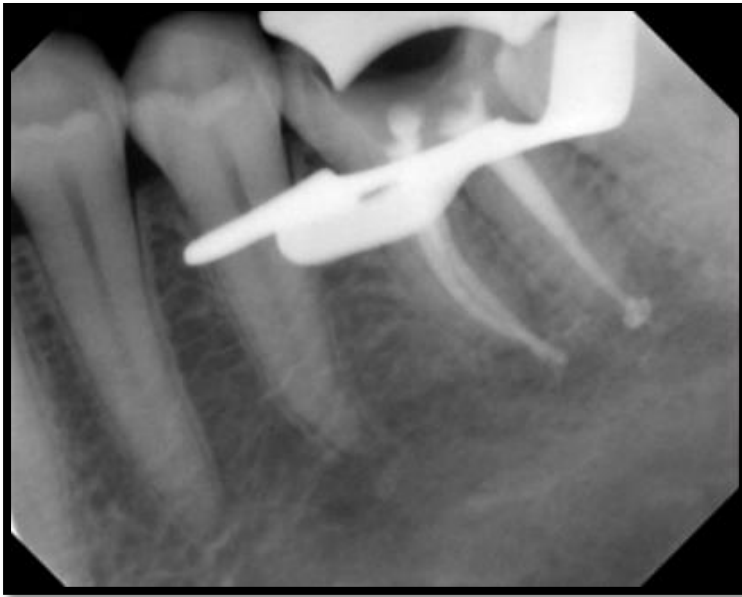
#16 Root Filling Terminating 0-2 mm from the Radiographic Apex
